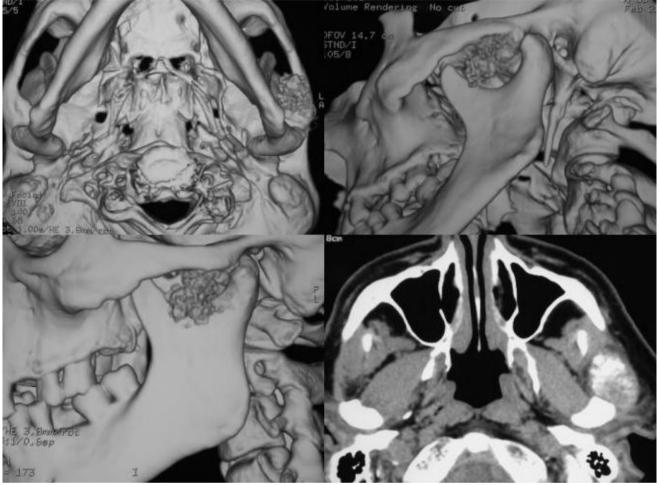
CT scan and 3D reconstruction showing the mass arising adjacent to the temporal condyle, with extension into the infratemporal fossa.
